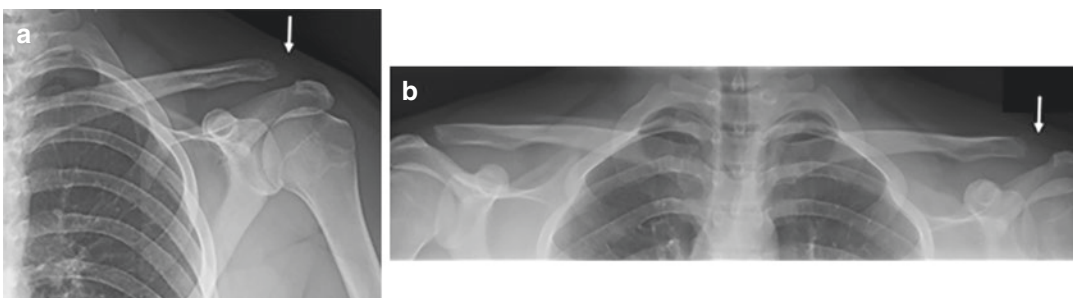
Standing radiographs of a type III left shoulder acromioclavicular joint (AC) injury. Image (a) is a left shoulder antero-posterior radiograph demonstrating an AC joint injury (white arrow). Image (b) is a bilateral
